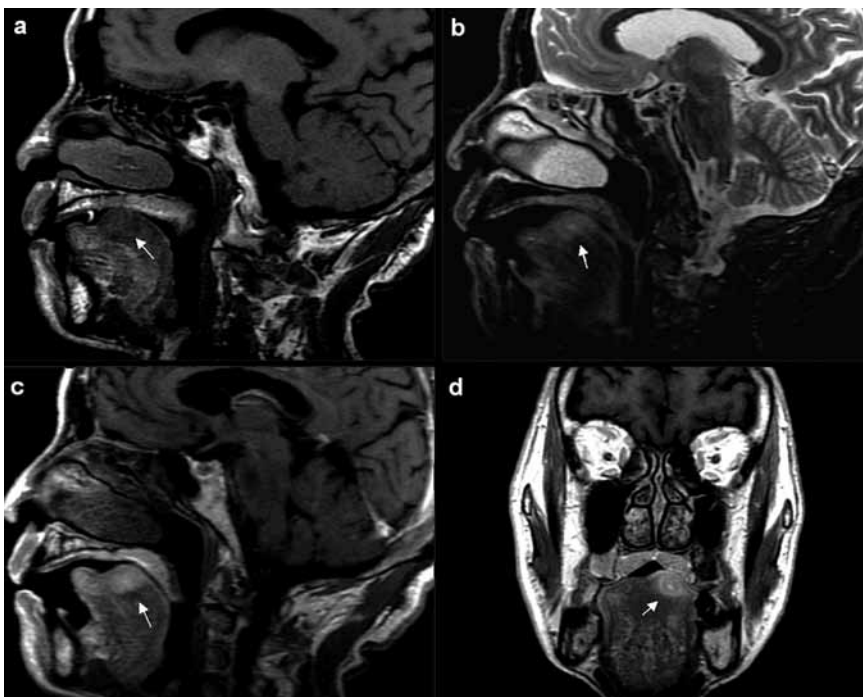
Magnetic resonance imaging of the tongue mass. An ill-defined mass in the left tongue base was found in the sagittal T1-weighted images a and T2-weighted MR image b, which was isointensive and hyperintensive compared to normal (arrow). A sagittal gadolinium-enhanced T1-weighted MR image c showed an enhancing mass with a diameter of 1.0 cm, and a coronal T1-weighted MR image d revealed the heterogeneously enhanced mass with a pattern of target sign (arrow).
